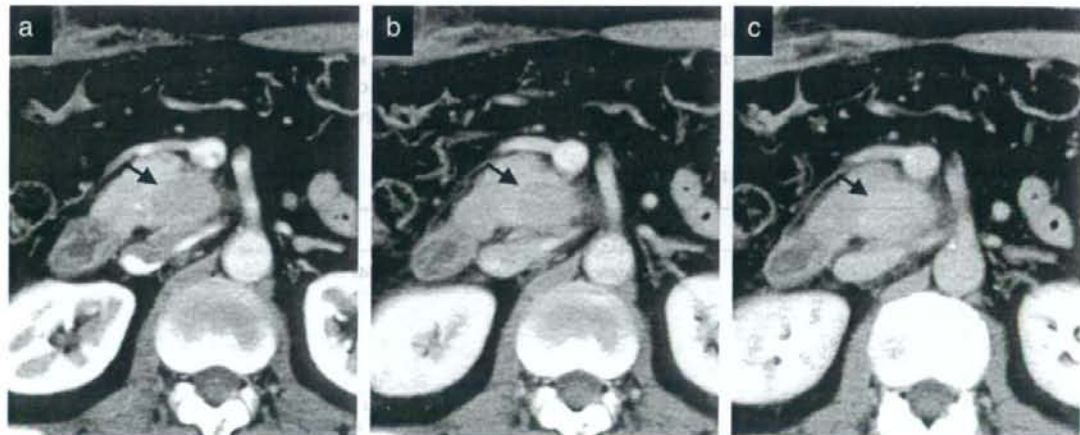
Dynamic computed tomography (CT) in case 3 shows a distinct mass lesion in the head of the pancreas with delayed enhancement (arrows). (a) Arterial phase, (b) portal phase, (c) delayed phase.
